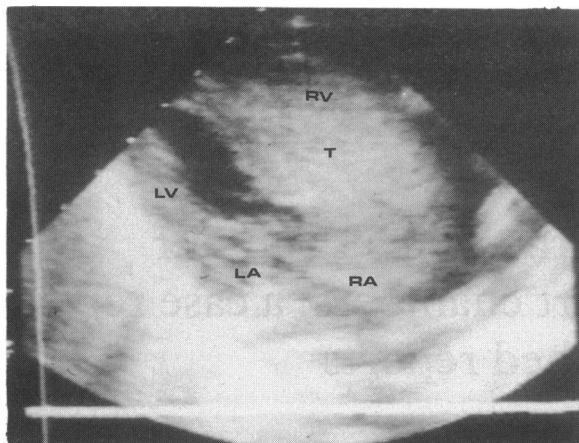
Figure Echocardiogram (apical four chamber view) showing tumour within right atrium prolapsed through to the right ventricle. T, tumour; RV, RA, LV, LA, heart chambers.
